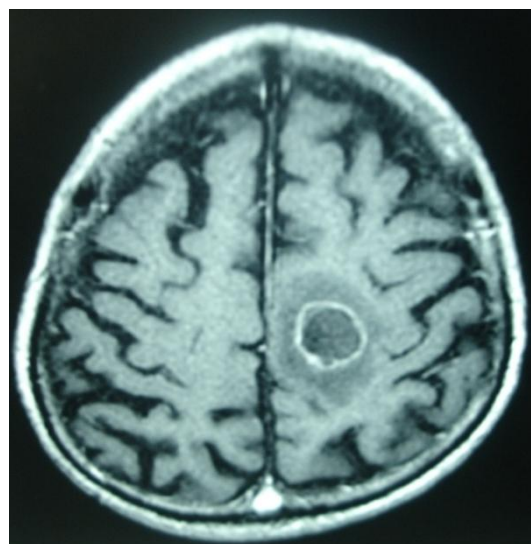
CT image – cerebral abscess surrounded by brain edema
